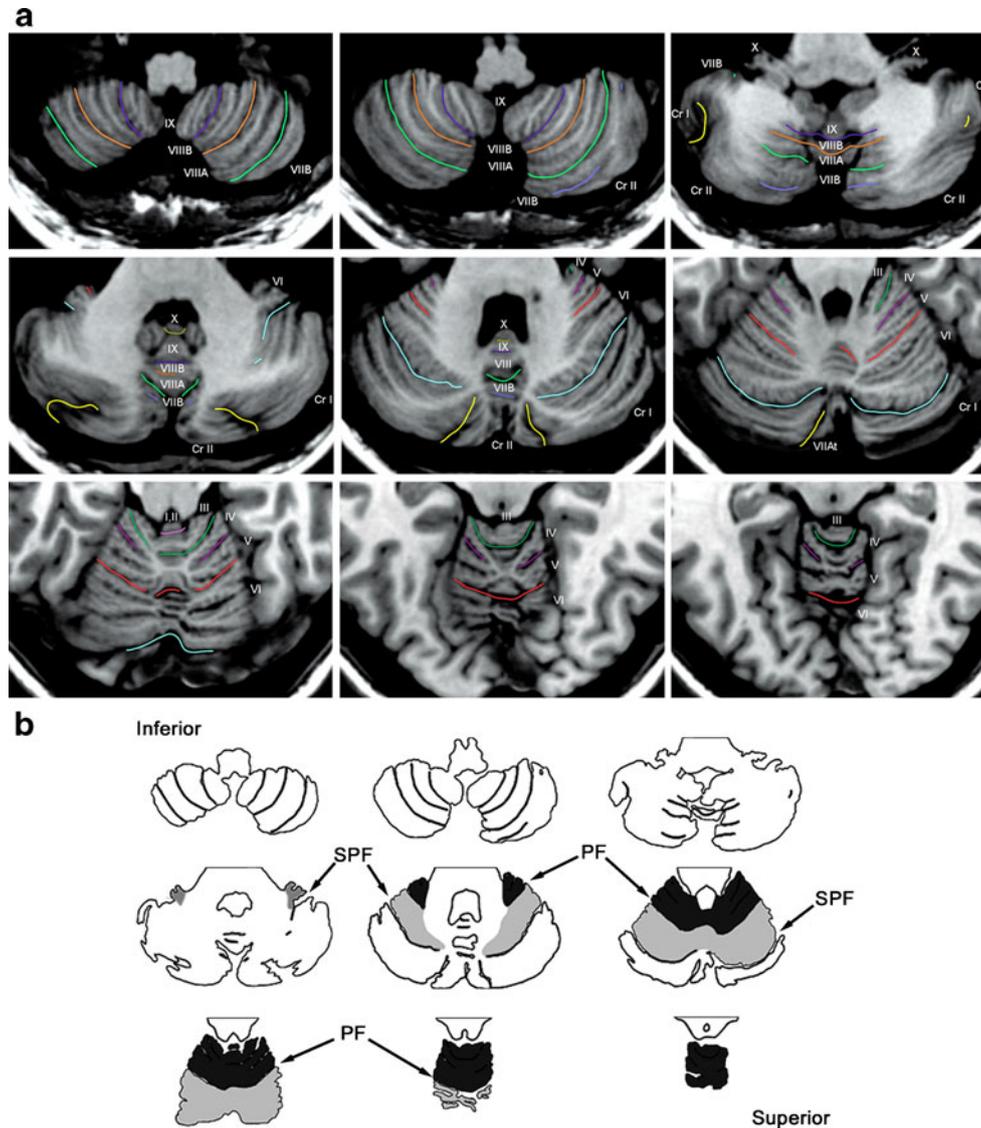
a Selected horizontal MRI images through the cerebellum with fissures and lobules identified. Inferior (posterior lobe) at top left, to superior (anterior lobe) at bottom right. Fissures are color coded: pink, precentral fissure (f), between lobules I/II and lobule III; light green, preculminate f, between lobules III and IV; purple, intraculminate f, between lobules IV and V; red, primary f, between lobules V and VI; light blue, superior posterior f, between lobule VI and crus I; yellow, horizontal f, between crus I and crus II; dark blue, ansoparamedian f, between lobules VII B and VIII A; dark green, previventer f, between lobules VIII B and VIII A; brown, intraviventer f, between lobules VIII A and VIII B; mauve, secondary f, between lobules VIII B and IX.
